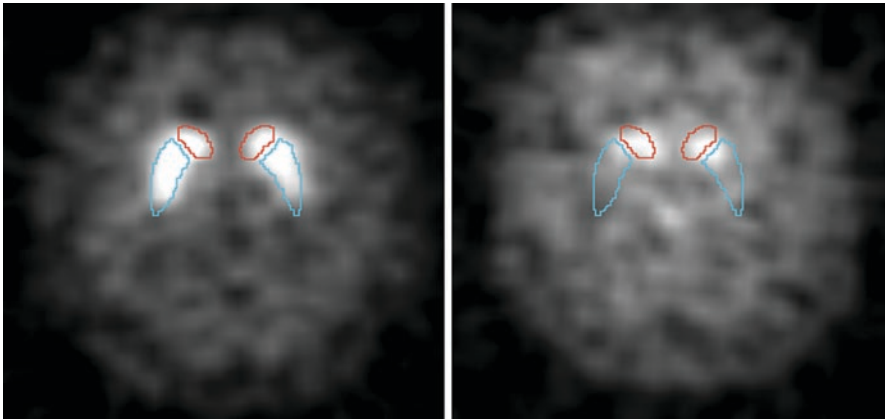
Two transaxial slice images taken from two DaT SPECT examinations of two different patients. On the left, there is a typical normal uptake distribution throughout the striatum (including caudate and putamen) from a patient with no dopaminergic degeneration. On the right, very abnormal uptake is demonstrated within both striata of a patient (more intensely reduced in the putamen) with bilateral nigrostriatal degeneration. The red and blue contours delineate the caudate and putamen, respectively
